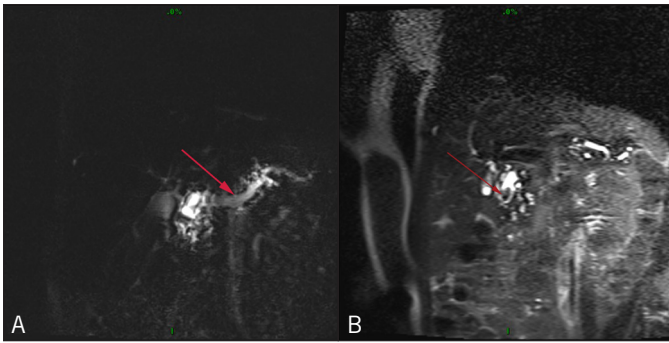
Abdominal MRI showing (A) dilated pancreatic duct downstream from pancreatic stone, and (B) a stone in the pancreatic duct.
